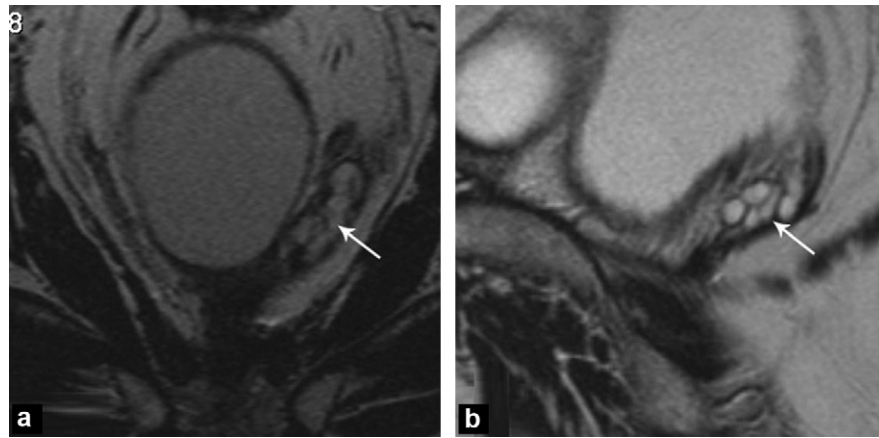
A 70-year-old patient who had had a radical prostatectomy 3 years previously for a Gleason 8 prostatic adenocarcinoma. After surgery, the PSA nadir was 0.09 ng/mL. Gradual increase again to 0.2 ng/mL: a: T2-weighted coronal slice; b: T2-weighted sagittal slice. The magnetic resonance imaging (MRI) shows an almost intact seminal vesicle (SV) on the left. It has a normal T2 fluid signal (white arrow). Dynamic MRI (not shown) did not show any suspect enhancement of this seminal vesicle.
